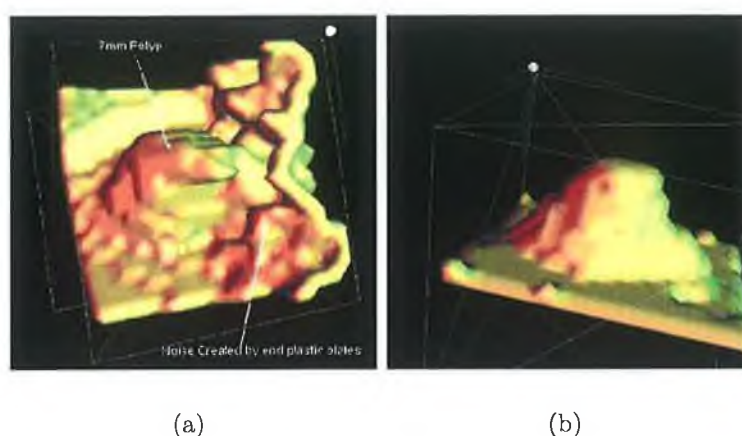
(a) Polyp undetected by the *CAD-CTC* algorithm when the *CT* data was acquired using the Protocols 1, 3 and 6. (b) Polyp undetected by the *CAD-CTC* algorithm when the data was acquired using the Protocols 2, 4 and 5.
